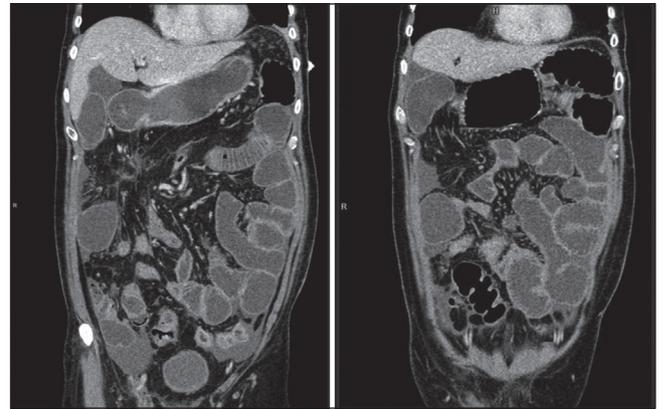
CT: rotation and thickening of epiploic vessels, mesocolic fat edema and mild small bowel dilatation. Coronal cuts.
